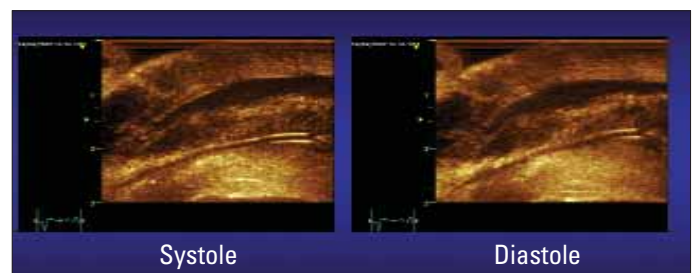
High- resolution image of septum line that has space or plane between the bands of muscle on either side of this dimension. The right ventricle is above. Note that the endocardial muscle region (below) is homogeneous and dense, while the epicardium region (above toward the RV outer wall) is more transparent, thereby reflecting how the echocardiographic beam traverses muscle fiber orientation planes that exist orthogonal or parallel to its direction. This plane separates the inner and outer segments undergoing reciprocal clockwise and counterclockwise twisting motions when the heart is ejecting and filling.
